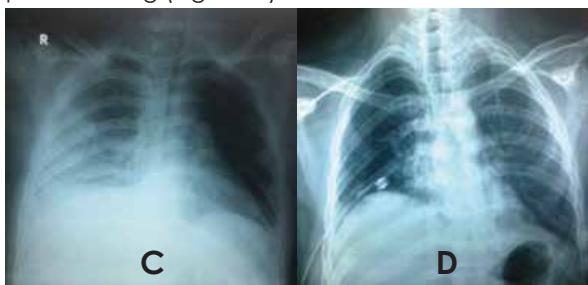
Chest X-ray 11th postoperative day (after removal of Nephrostomy) showing right hydrothorax, Figure D: Chest X-ray on 10th postoperative day showing no residual intrapleural collection.
